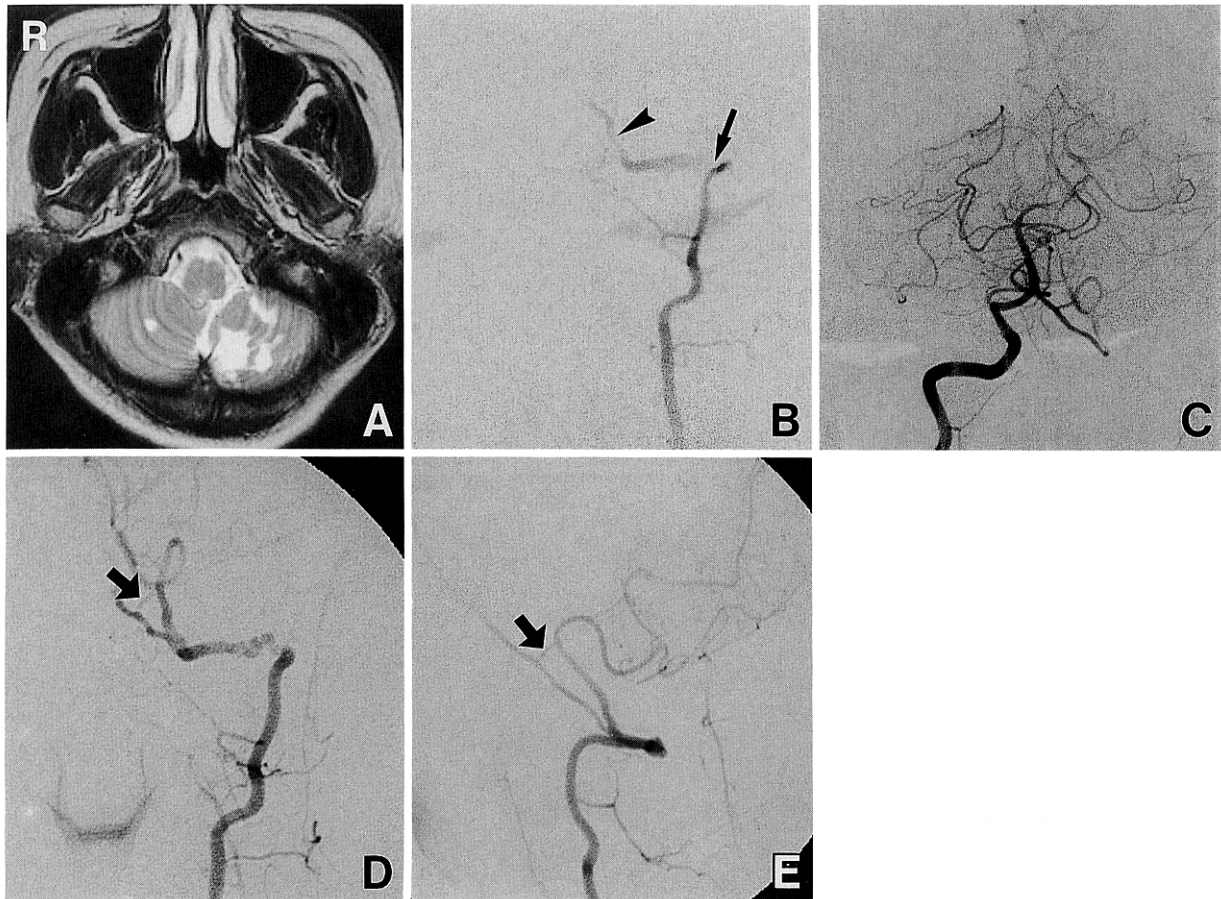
Case 1. Magnetic resonance image taken 1.5 months after ictus (A) showing bilateral inferior cerebellar infarctions (left > right). Left vertebral angiogram at the same time (B: frontal view) showing dilative change in the V_3 segment (arrow) of the left extracranial vertebral artery and proximal leg (arrowhead) of the dual origin of the left posterior inferior cerebellar artery (PICA). Right vertebral angiogram at the same time (C: frontal view) showing retrograde filling of the dual origins of the PICA. Follow-up angiograms 2 years later (D: frontal view, E: lateral view) showing wall irregularity in the same V_3 segment and the dual origins of the left PICA. Thick arrow indicates the distal leg of the dual origin of the PICA.
